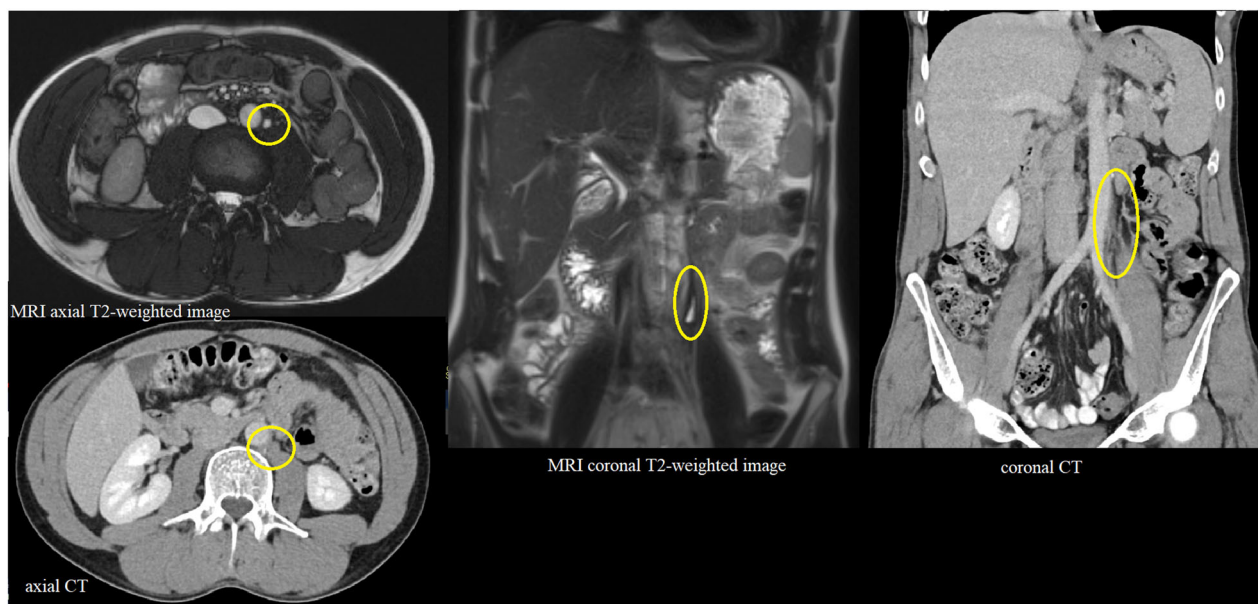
A 33-year-old man treated for a NSGCT with left radical orchidectomy, retroperitoneal lymphadenectomy and chemotherapy. On follow-up CT, a suspicious left-para-aortic retroperitoneal nodule was detected, but on MRI this turned out to be a T2-hyperintense post-operative seroma (white circle and oval). The CT findings were false-positive in this case
